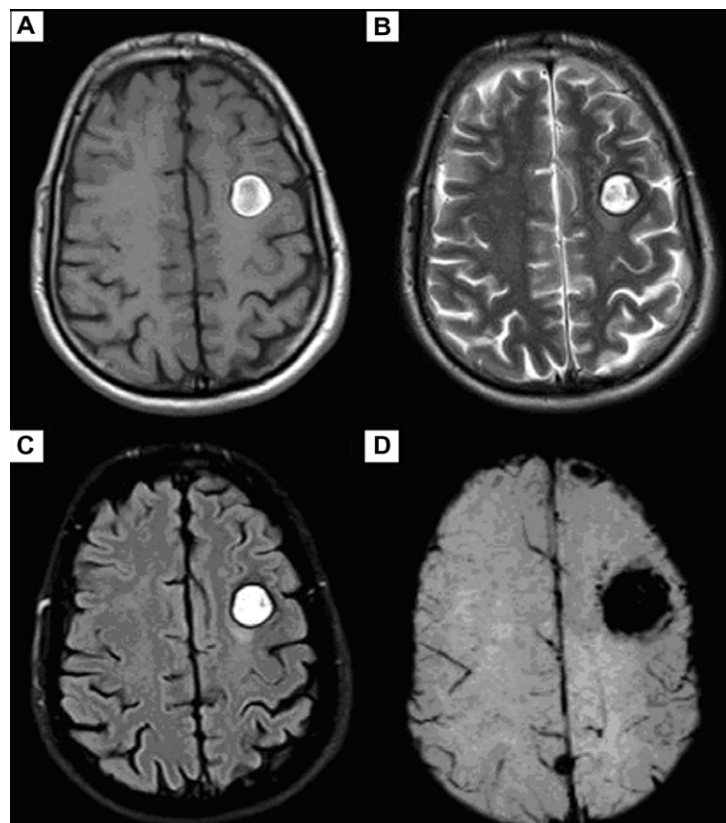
Fifty-five year old male patient presenting with altered sensorium. T1 (A), T2 (B) and FLAIR (C) show hyperintense left cerebral cavernoma with T2 hypointense hemosiderin ring seen within the left frontal lobe, SWI (D) confirms diagnosis and reveals another one in the right occipital lobe.
